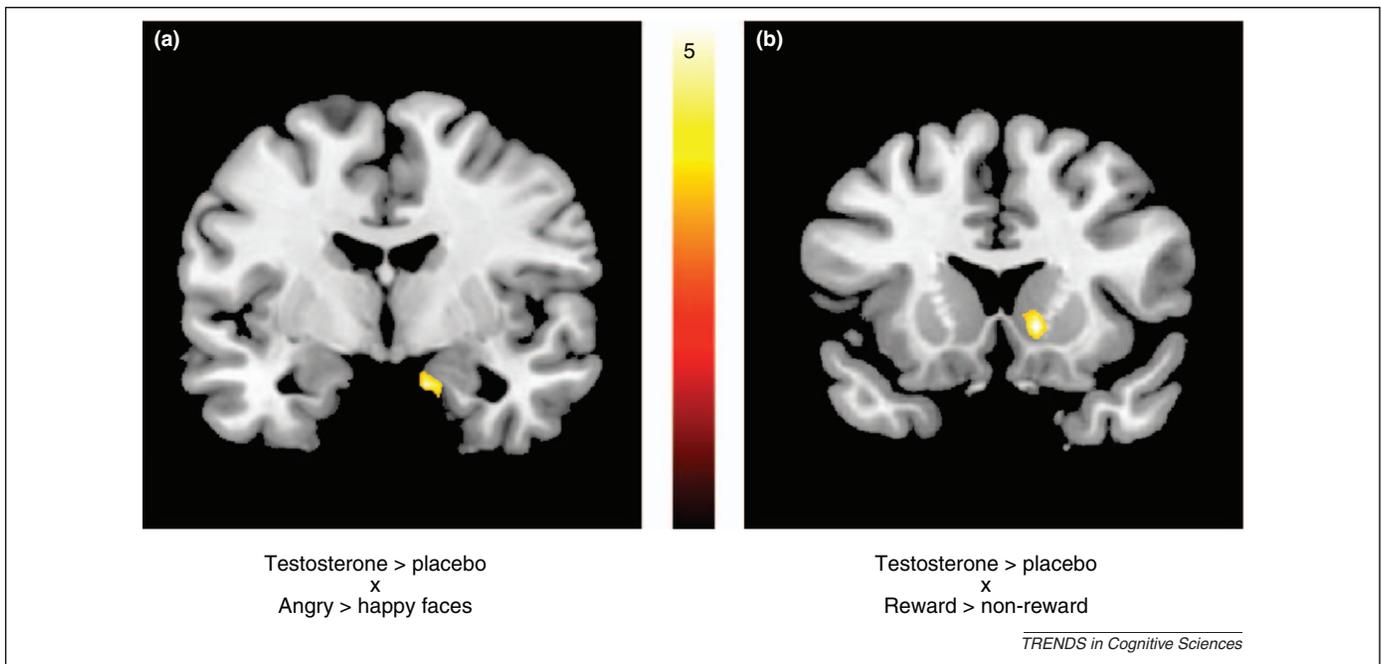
Testosterone-enhanced activation of the right amygdala in the contrast 'angry versus happy faces' (a). Enhanced activity of the ventral striatum after testosterone administration in the contrast 'reward versus non-reward' trials (b). Both images are overlaid on a canonical T1-weighted anatomical image. Adapted from [66] (a) and [82] (b).
